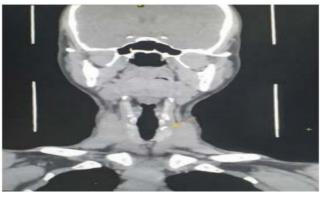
CT neck showing foreign body (arrow).
